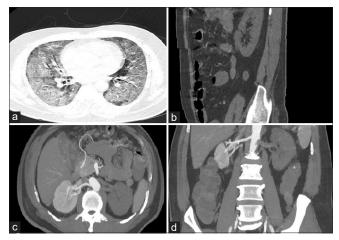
(a) CT Lung showing Bilateral ground glass opacities. (b) Saggital view showing non-enhancing left kidney. (c) Axial view showing enhanced right renal artery and non-enhanced left kidney and renal artery. (d) Coronal view showing enhanced right renal artery and non-enhanced left renal artery and non-enhanced left renal artery and left kidney
